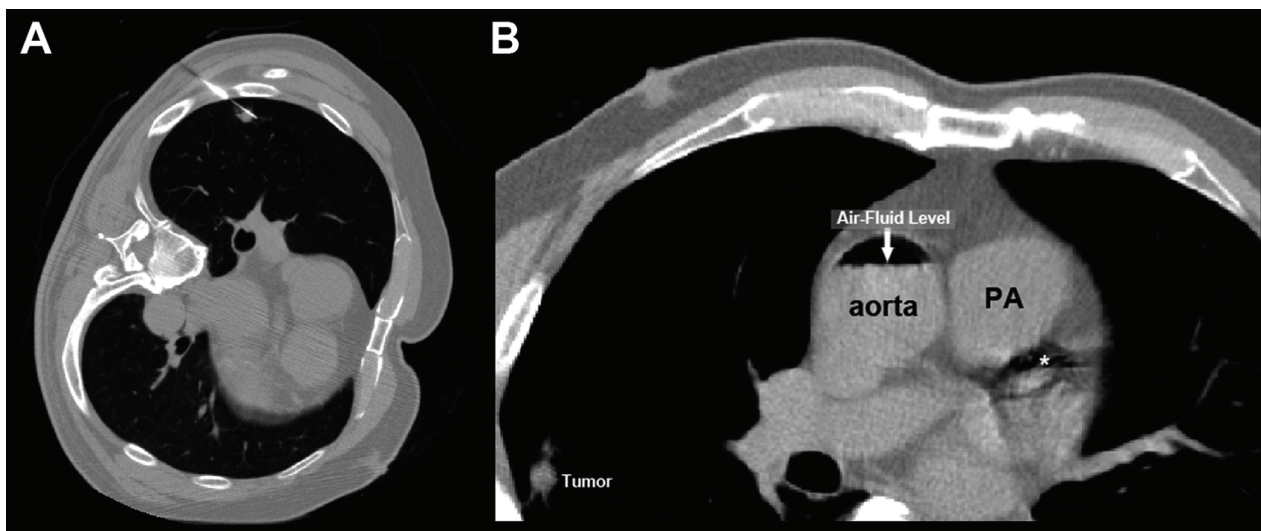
Chest computed tomography-guided transthoracic needle biopsy (Figure 1A), intra-aortic air-fluid level (Figure 1B, arrow), and air bubble in the left anterior descending coronary artery (Figure 1B, star).
